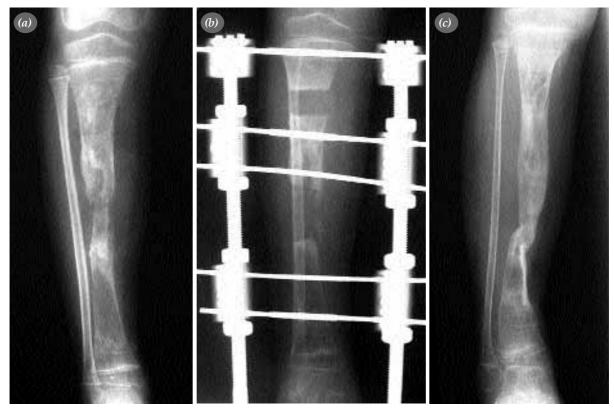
(a) A-P tibial x-ray of a case with chronic OM developed after hematogenous spreading , presenting the large sequester an no involucrum formation (b) Segmentary defect was reconstructed by distraction-compression osteogenesis method, bilateral uniplanar external fixator was used, lengthening was performed selectively on tibia, the external fixator pins were applied directly to tibia, missing the fibula on purpose. (c) x-ray of the same case after the healing was completed.
